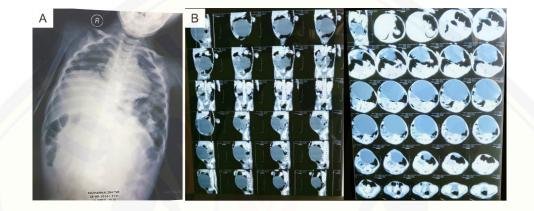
Abdominal radiograph and upper gastrointestinal examination of case 2. A. In the abdominal radiograph, we found a soft tissue density at the center of the abdomen displacing bowel loops. B. Abdominal tomogram shows a unilocular cystic intraperitoneal tumor with dimensions $5.53 \times 9.32 \times 9.3$ cm in size.
